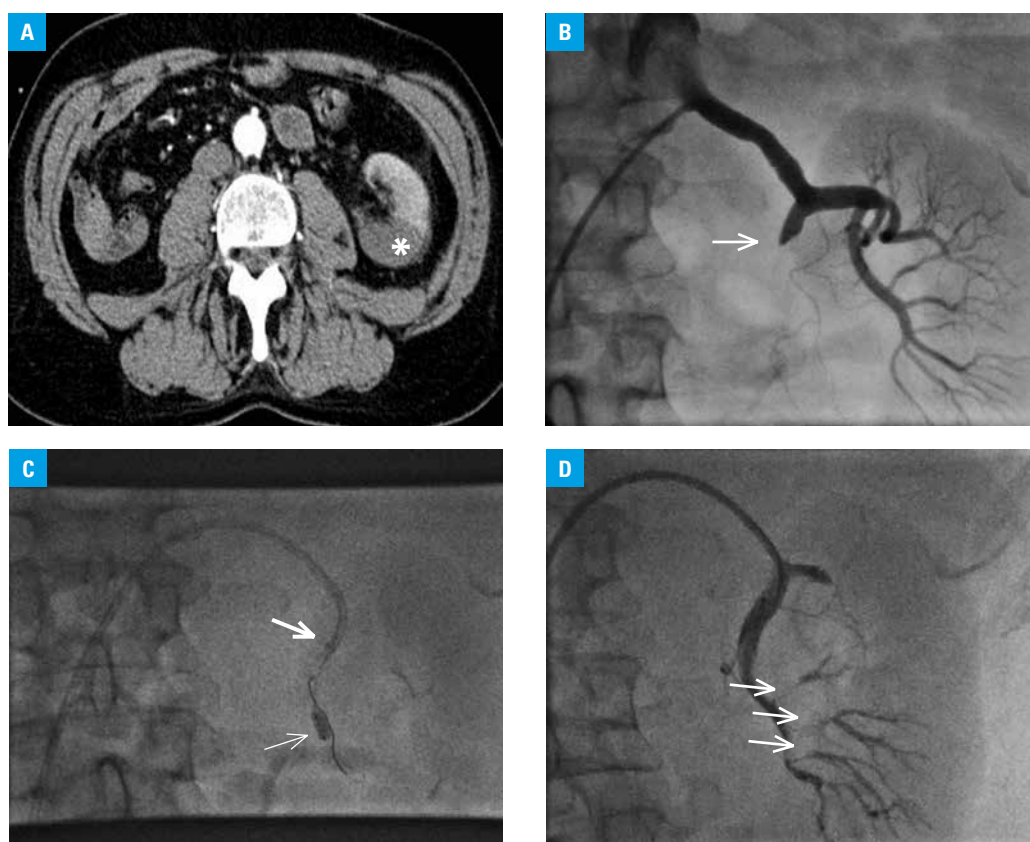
A – computed tomography scan: a hypodense area involving the dorsal part of the left kidney (asterisk); B – angiography: occlusion of the posterior branch of the left renal artery (arrow); C – thrombus aspiration with a guiding catheter (arrow) with simultaneous balloon inflation beyond the site of the occlusion (thin arrow); D – angiography: a reopened branch with thrombus remnants located distally (arrows)
